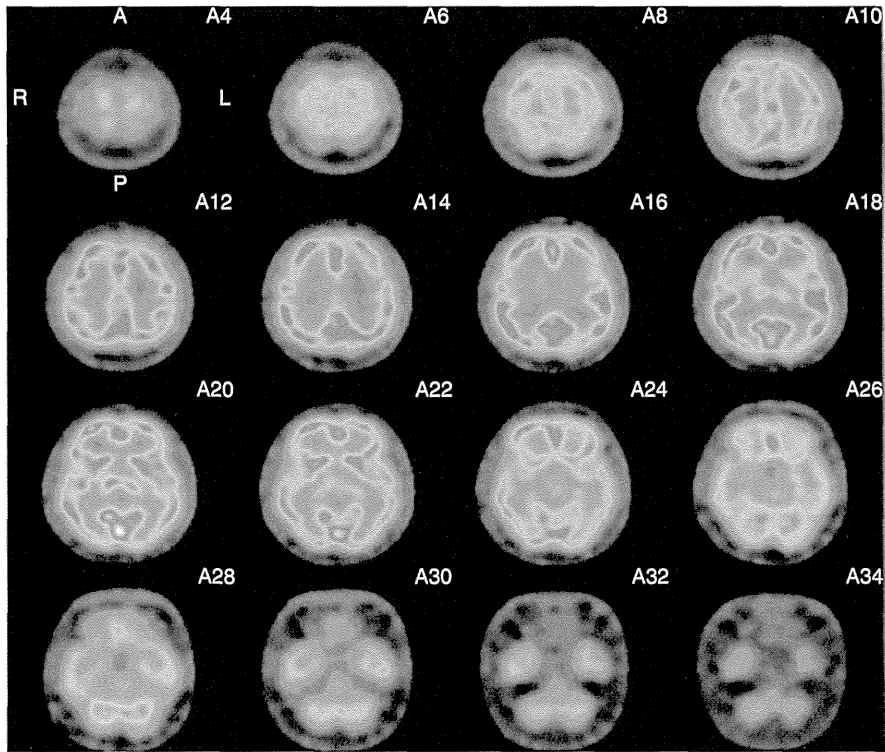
Single-photon emission computed tomography findings. SPECT of a patient (III-15) shows blood flow reduction in the cerebellum.
